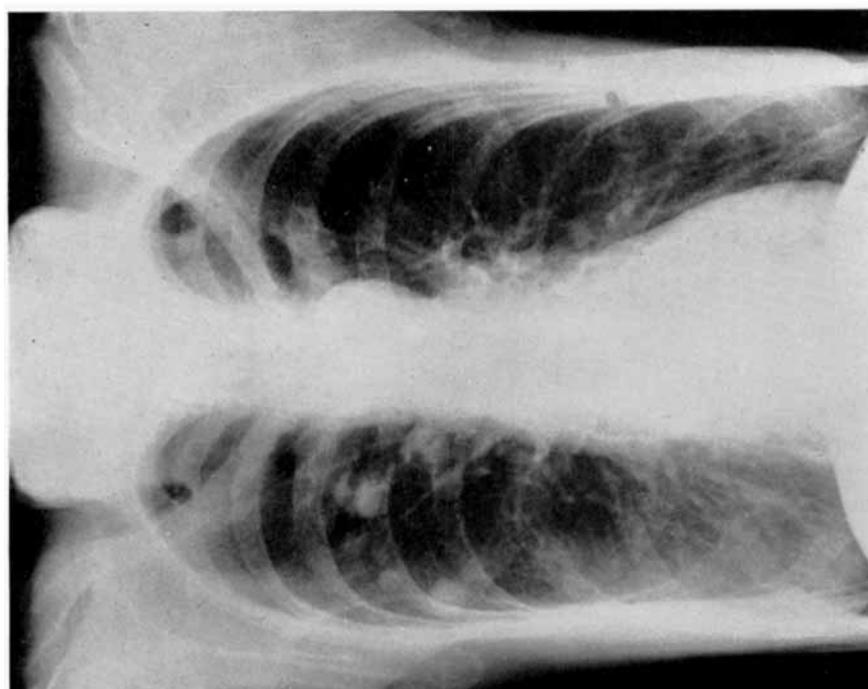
X-ray photograph of chest in March 1948, showing general rarefaction of bones and several well-defined rounded shadows in the upper half of the right lung.
